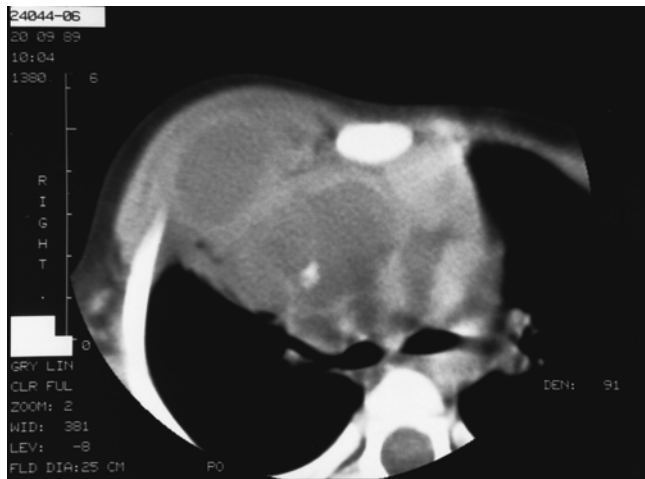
A 2 year old was referred for a 5 cm by 5 cm hard fixed right chest wall mass that appeared suddenly during an upper respiratory infection. The computed tomography scan shows a bilobed lesion that extends through the chest wall and contains a small area of calcification. An incisional biopsy revealed pus-like material, containing ghost cells and calcified debris. Serum markers were normal. Complete excision of the mass required a right anterior thoracotomy and partial resection of an adherent right middle lobe. Pathologic examination revealed a ruptured mature teratoma with marked inflammatory reaction, containing foci of enteric, respiratory, and squamous mucosa; smooth muscle; salivary glands; pancreas; neuroglial tissue; and bone (Reproduced with permission from page 983 of: Laberge et al. [90])
